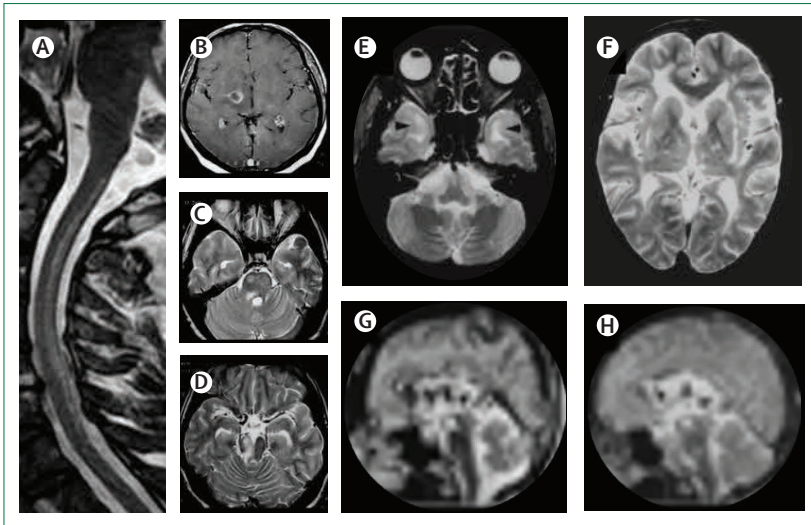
MRI scans of patients with nutritional deficits or diseases with genetic backgrounds that mimic multiple sclerosis
